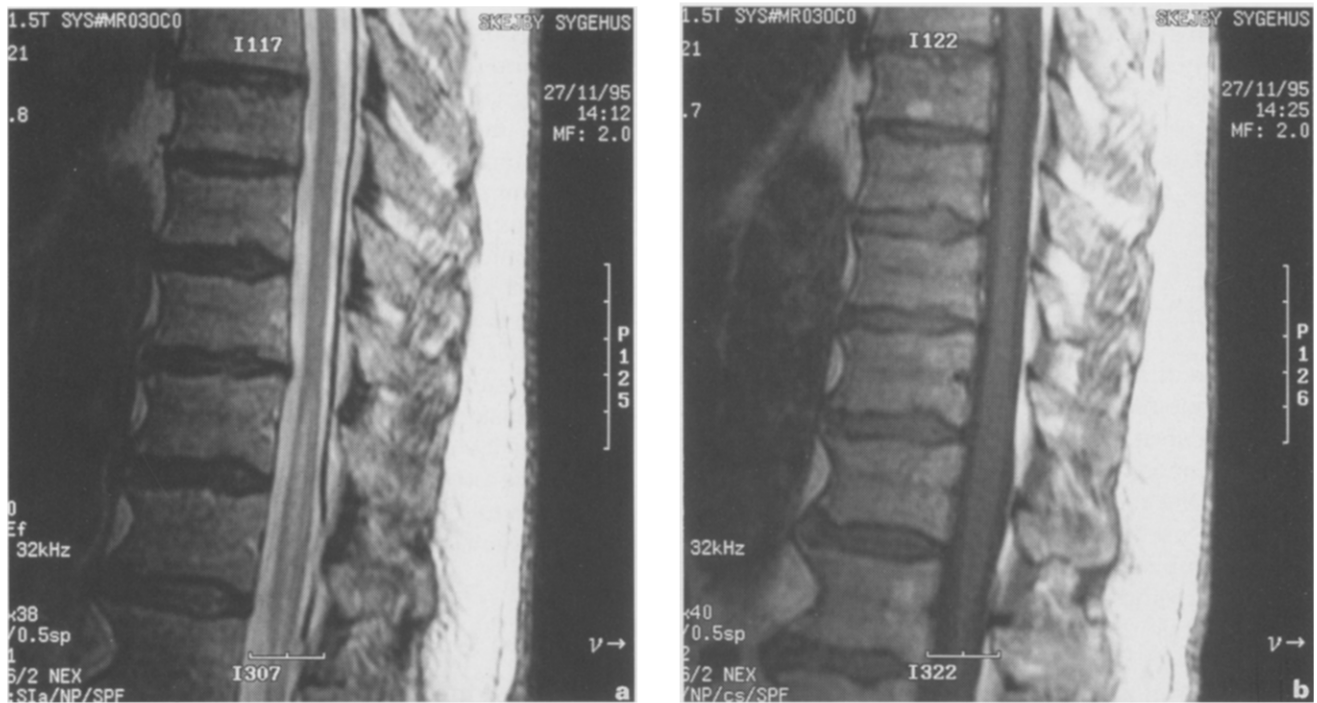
Case 1 Medullary infarction. Area of high signal intensity on a T2-weighted sequence (a) and low signal intensity on T1-weighted sequence (b), together with a slight increase in spinal cord volume
